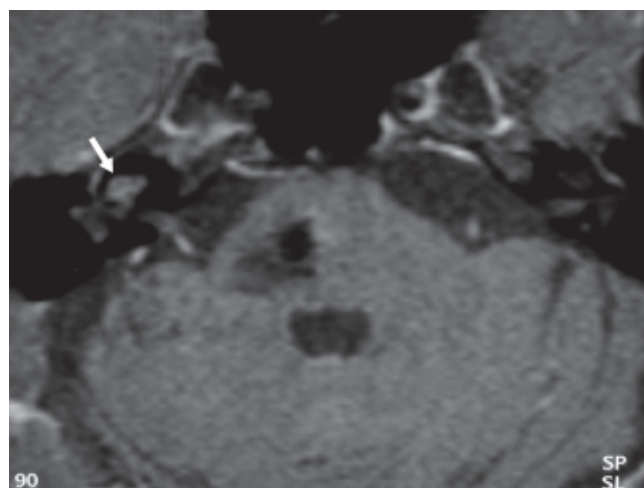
Contrast-enhanced T1-weighted axial image at the same level showing no appreciable increase in the high signal in the right cochlea (white arrow).
